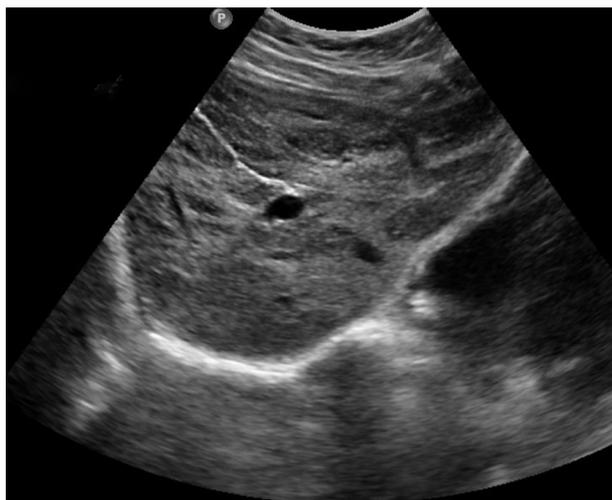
Ultrasound liver (after 9 mo) complete resolutions of earlier liver lesions.
